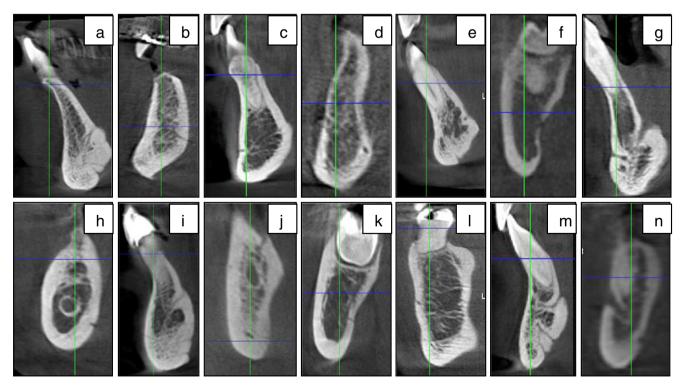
Examples of CBCT images with identifiable accessory canals (all images are at 200- $\mu$ m resolution except for d and j that are at 400- $\mu$ m resolution, and for f and n that are at 600- $\mu$ m resolution)
